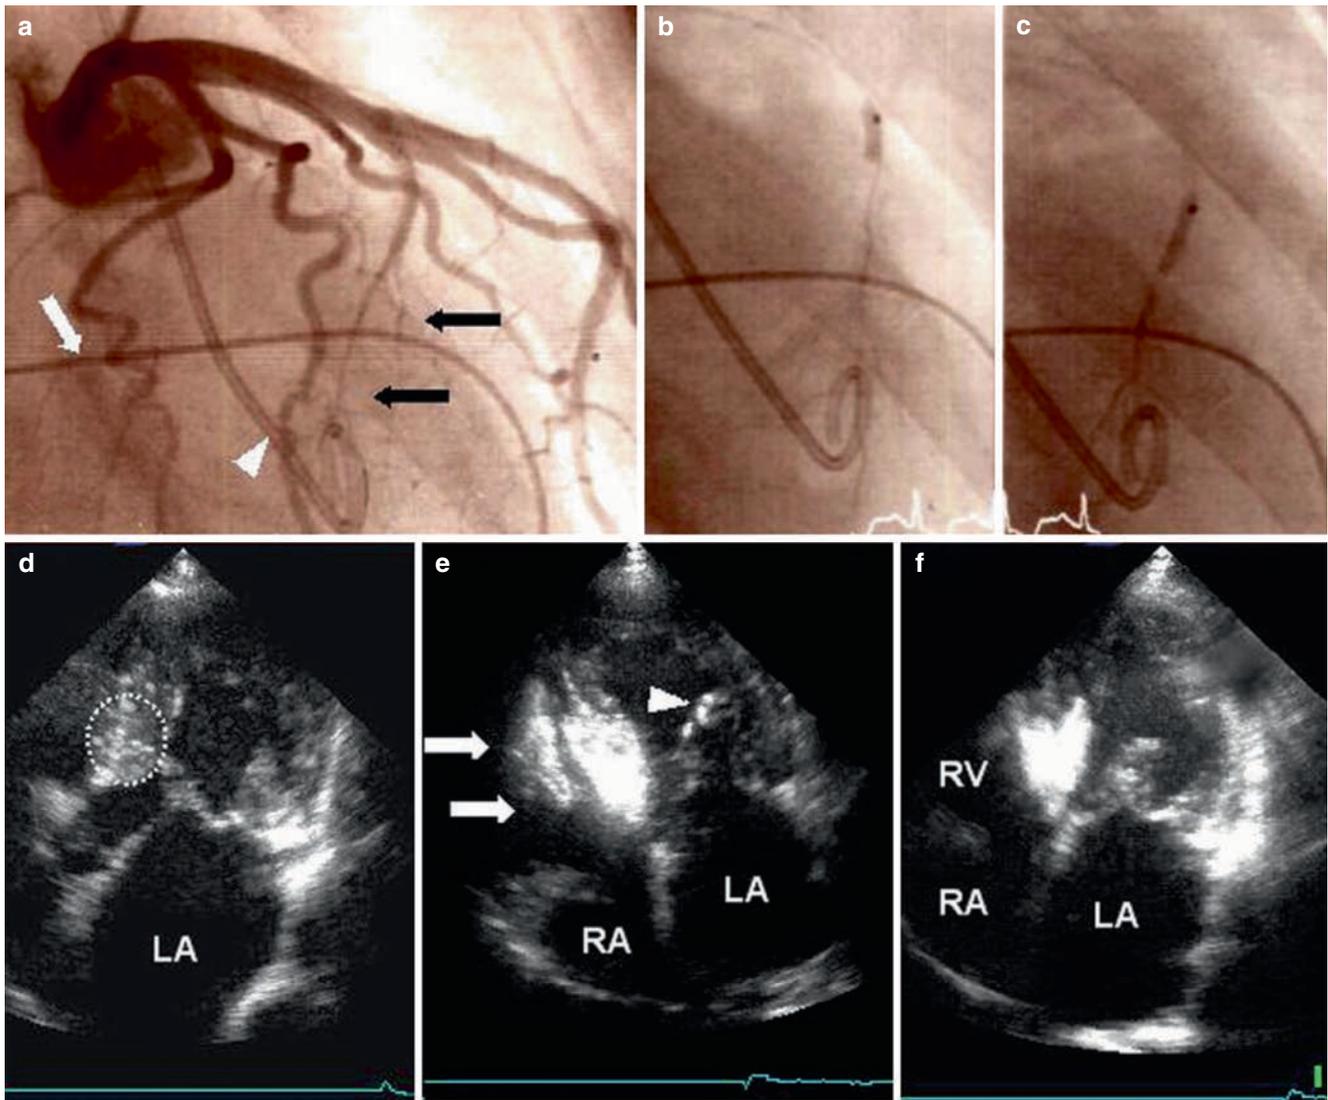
Interventional and echocardiographic sequence of a (super-selective) septal ablation procedure for symptomatic hypertrophic obstructive cardiomyopathy. Angio sequence: first major septal perforator artery with two sub-branches (*black arrows*), as the presumed target vessel (a), *white arrow*, lead of the temporary pacemaker; *white arrow*, pigtail catheter in the LV, balloon within the proximal part of the septal perforator, (b) distal vessel bed with two sub-branches contrasted angiographically, (c) balloon advanced
